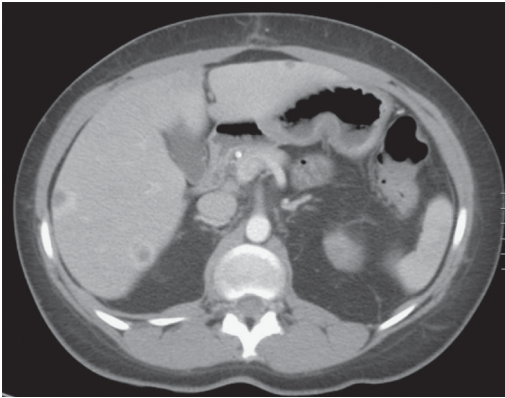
CT demonstrating multiple rim-enhancing hepatic lesions.
